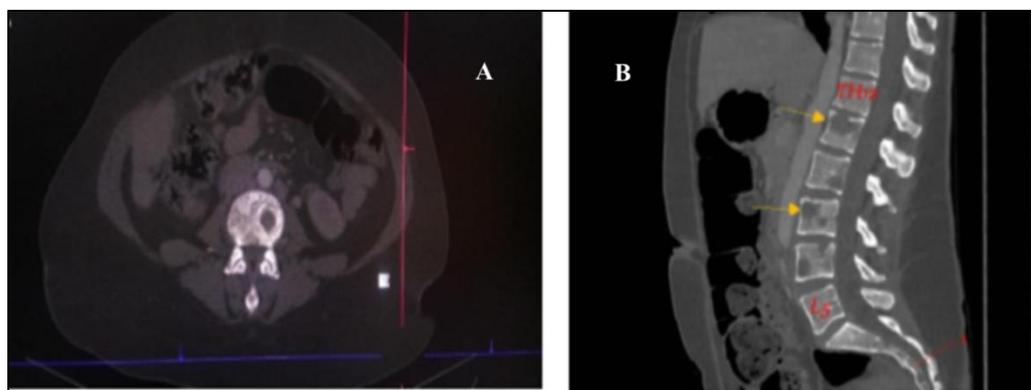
Abdominal CT in axial (A) and sagittal (B) section, in bone window without injection of contrast product, highlights multiple osteolysis on the lumbar spine (yellow arrow)
